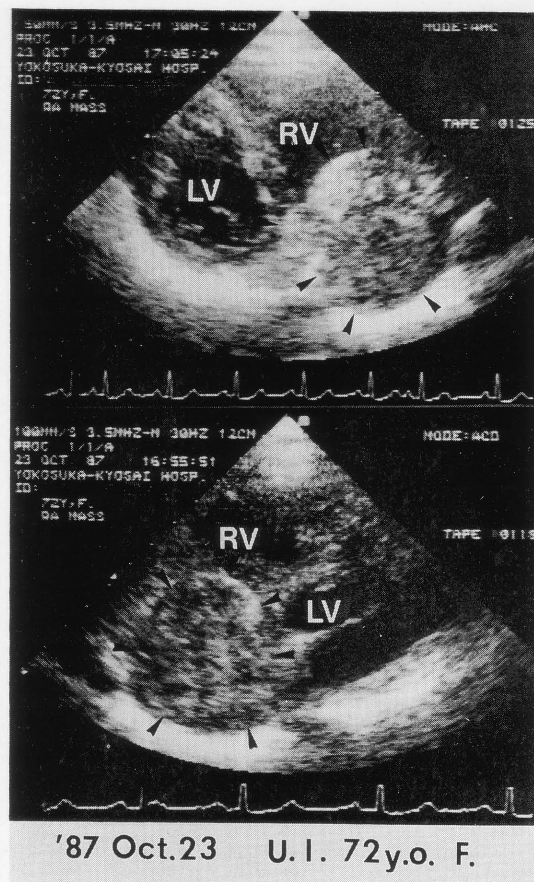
Two-dimensional echocardiogram showing poorly movable tumor, 6 × 5.5 cm.
